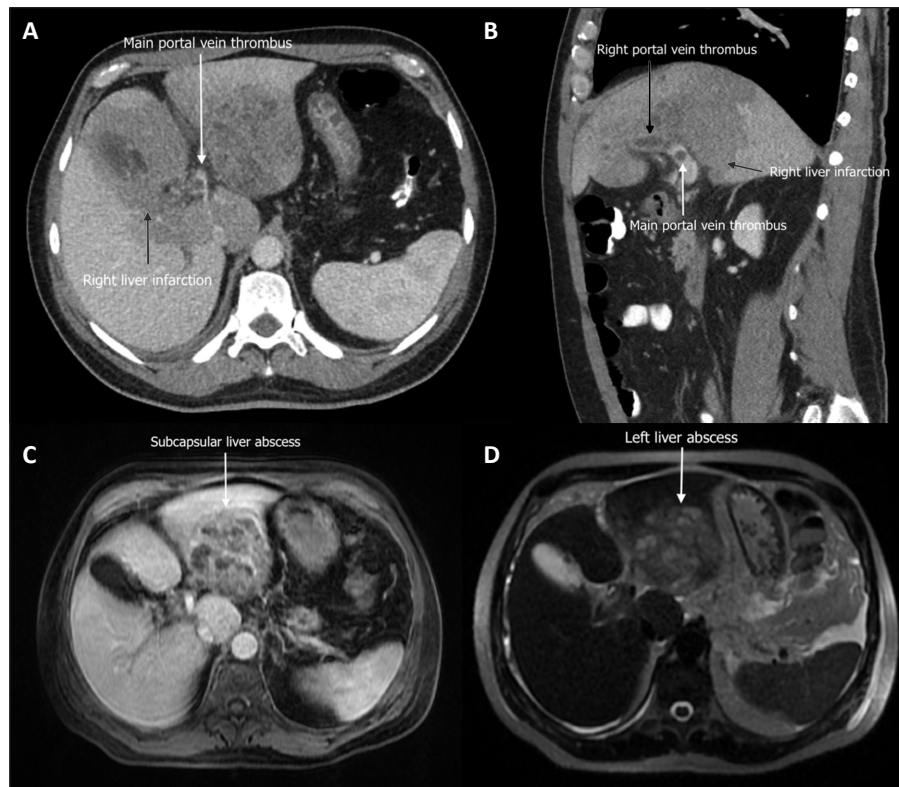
Abdominal CT scan in transverse view (A) and sagittal view (B). Main portal vein thrombus (white arrow) with a wedge-shaped area of hypoenhancement and altered perfusion involving the left liver and anterior right liver and compatible with infarction (grey arrow). T1-weighted (C) and T2-weighted (D) abdominal MRI in transverse view with evidence of a large multiseptated, mass-like lesion in the left liver lobe and compatible with a subcapsular liver abscess.
